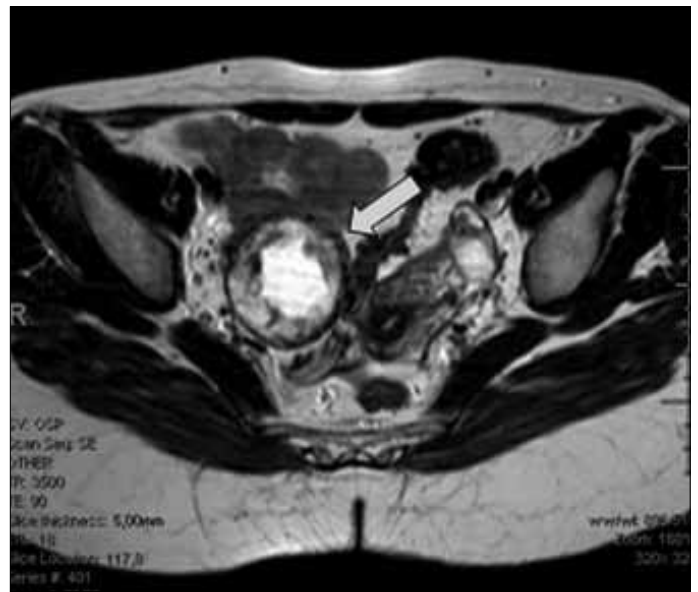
Arrow shows the magnetic resonance imaging of the adnexal mass.
